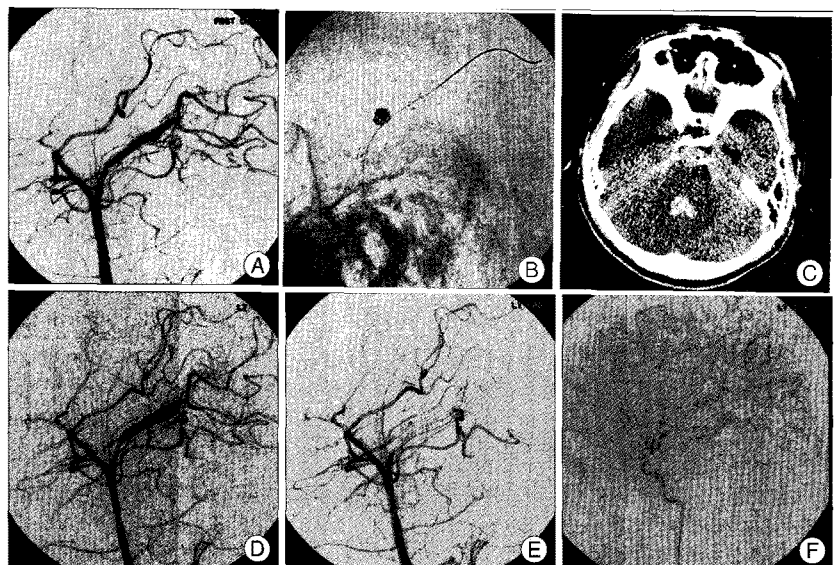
A and B : Vertebral angiogram oblique views showing two stents deployed in the left PCA and selectively occluded aneurysm with coils. C : Brain CT performed after clinical deterioration, revealing intraventricular and subarachnoid hemorrhage. D : Repeated angiogram oblique view revealing widening of the stented segment. E : The previously stented P2 segment was completely occluded. F : Left carotid angiogram lateral view showing collaterals to the PCA territory from the anterior circulation. PCA : posterior cerebral artery.
